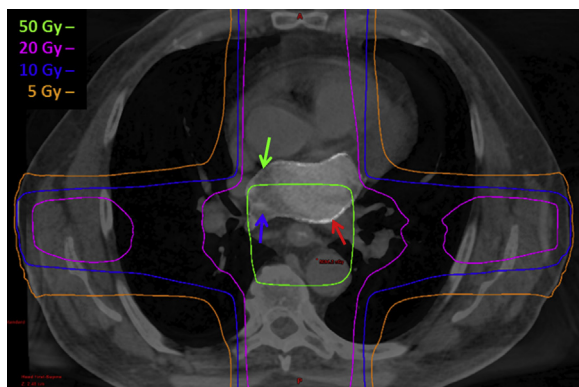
Treatment plan showing isodose distribution for treatment of the esophagus using 3-dimensional conformal four field technique overlaid on blended computed tomography/magnetic resonance imaging. Red arrow, left atrium scar; blue arrow, left atrium blood pool; green arrow, left atrium wall.
